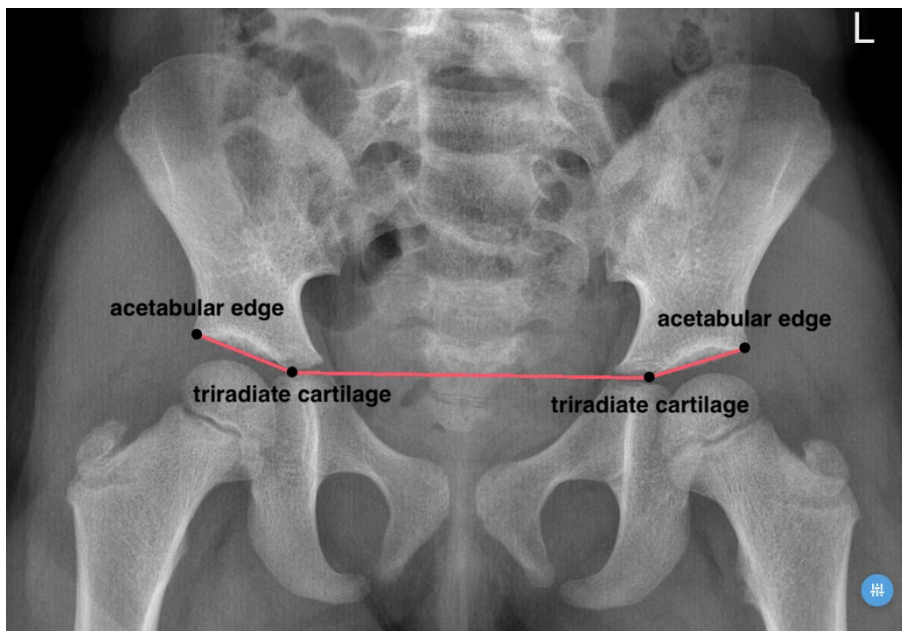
Identification of the AC angle in the radiograph
